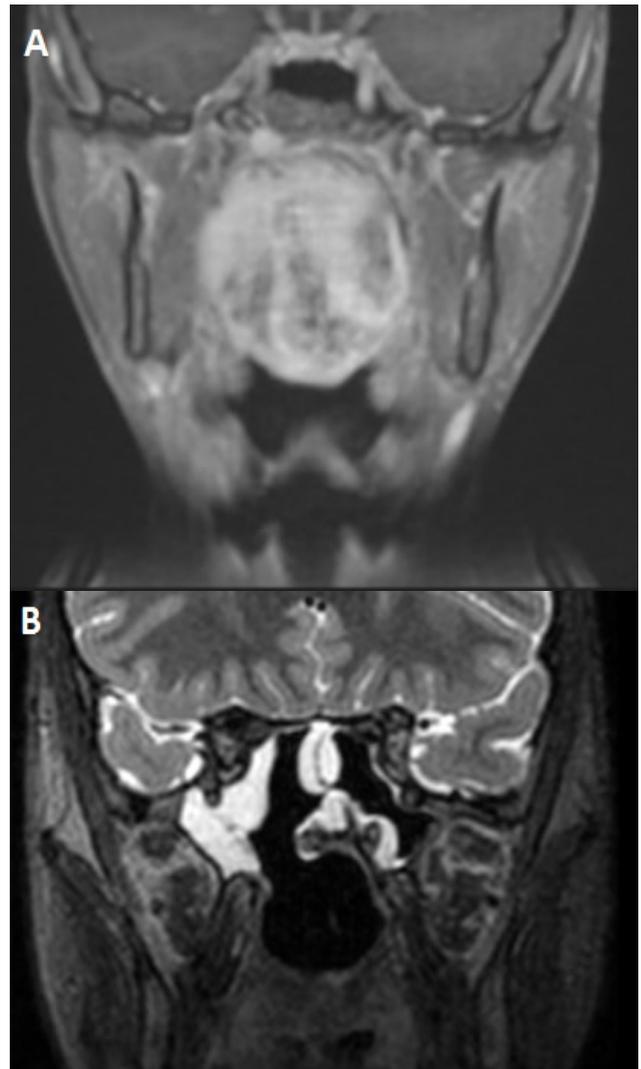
A) Preoperative postcontrast, T1 coronal MRI scan. B) Postoperative, T2 coronal MRI scan.
